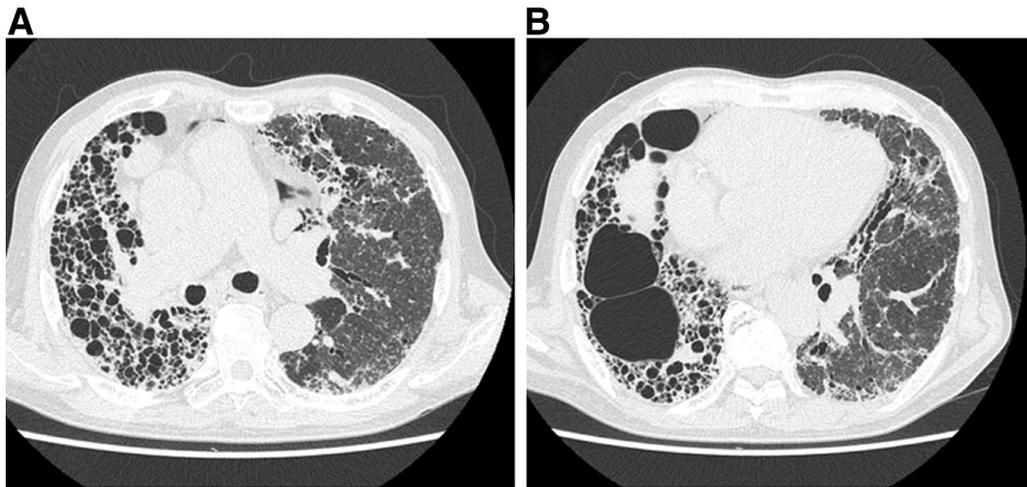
High resolution computed tomography showed massive traction bronchiectasia and honeycombing in bilateral lungs (A) (B).
